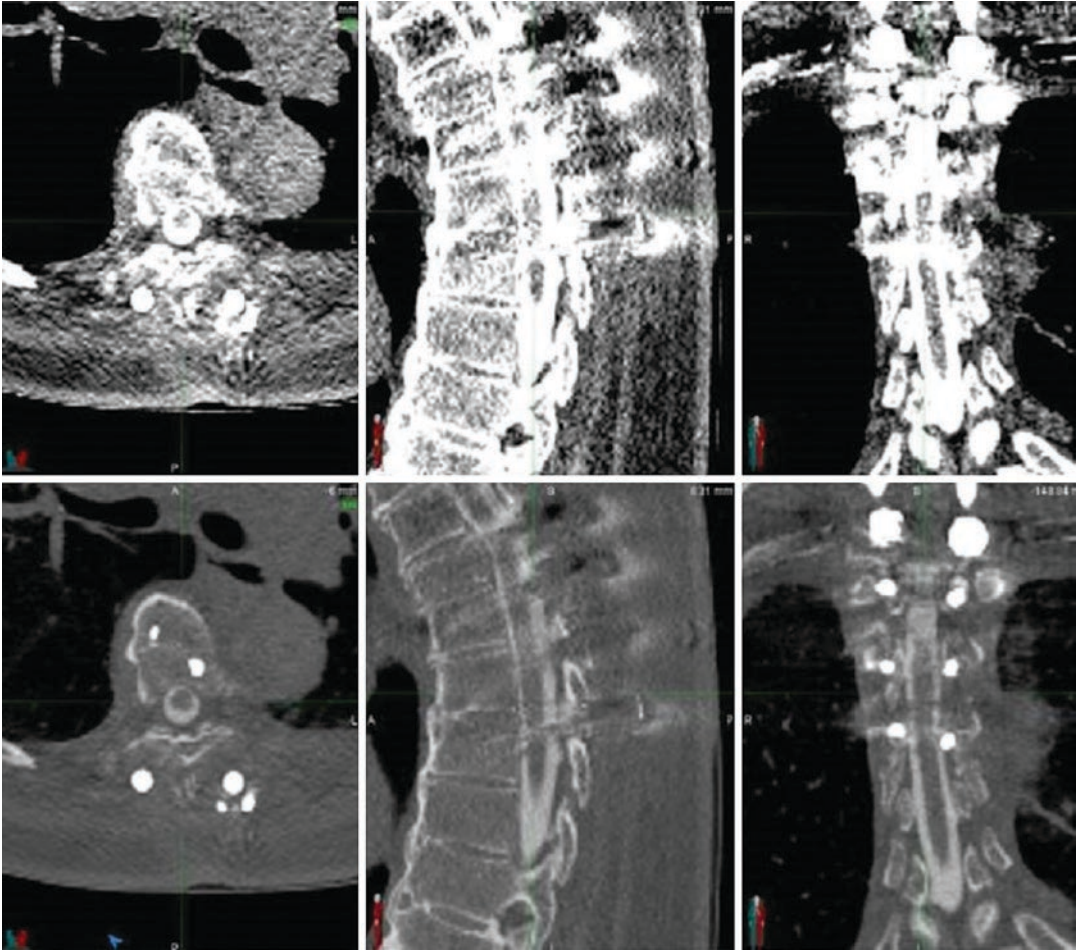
CT myelogram to aid delineation of the spinal cord. Upper panel, incorrect windowing with small cord contours; lower panel, correct windowing showing true cord contours
